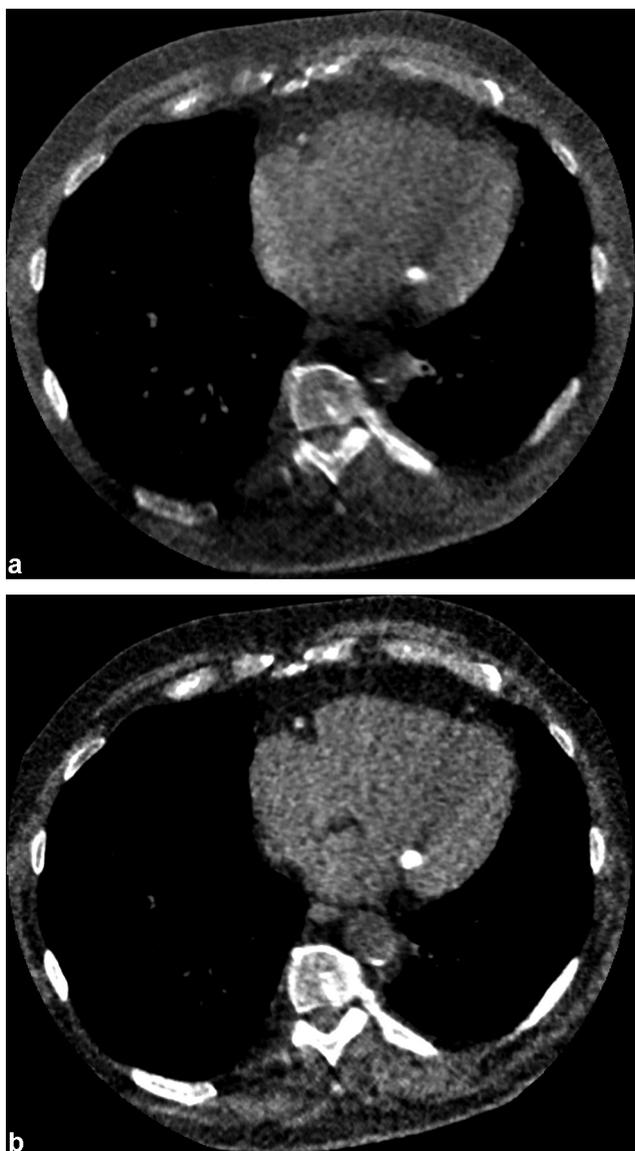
Ultra-low dose CT image of the chest in the transverse plane (mediastinal window) acquired at 80 kVp (a) and at 135 kVp (b) in a 74-year-old man with a body mass index of 32.7 kg/m². Image quality is significantly better at 135 kVp (b) than at 80 kVp (a).
